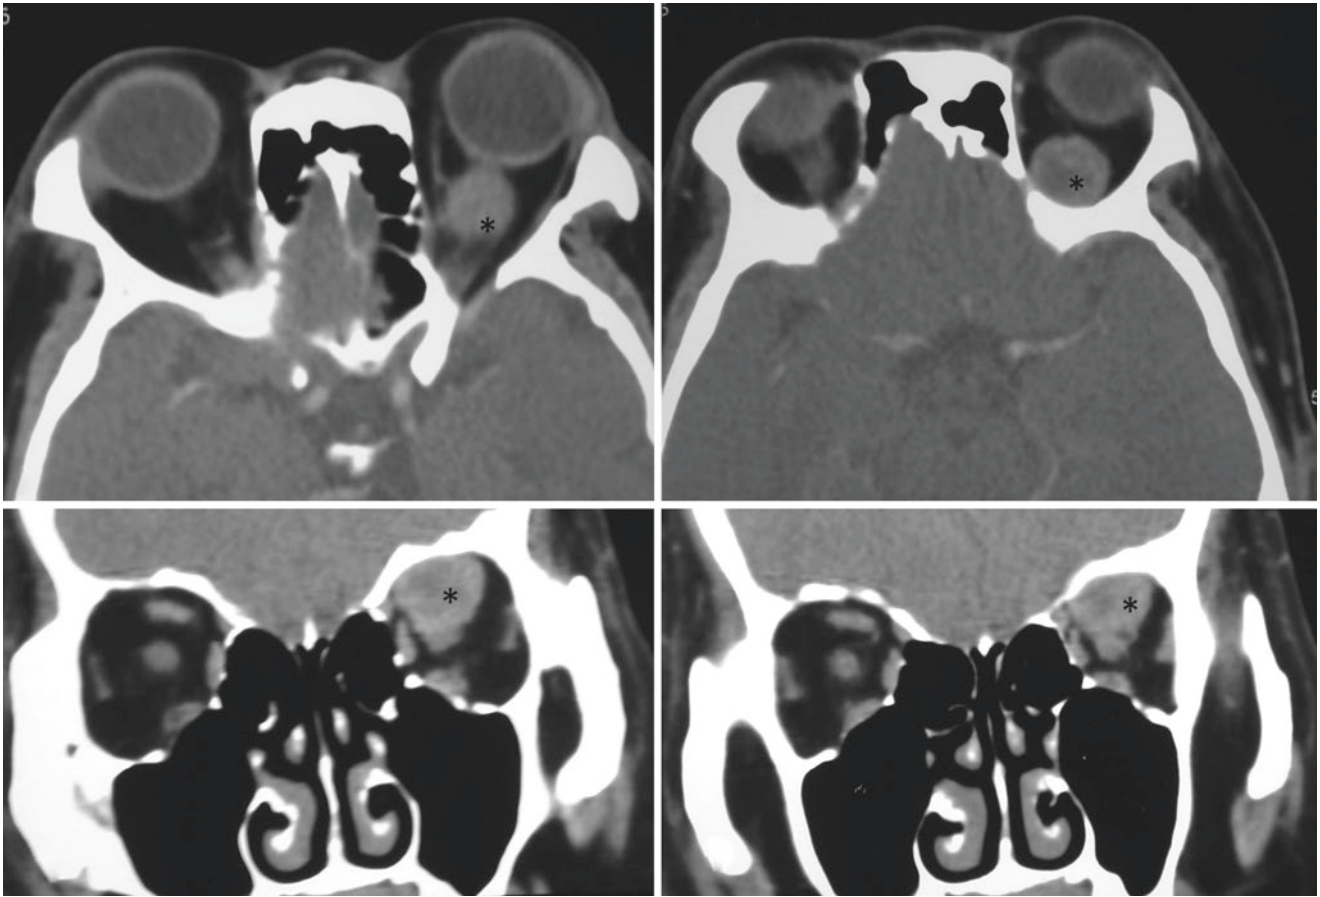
Axial and coronal CT scans (6 weeks after initial presentation) show enlargement of the mass in the superior muscle complex on the left side (asterisk)
